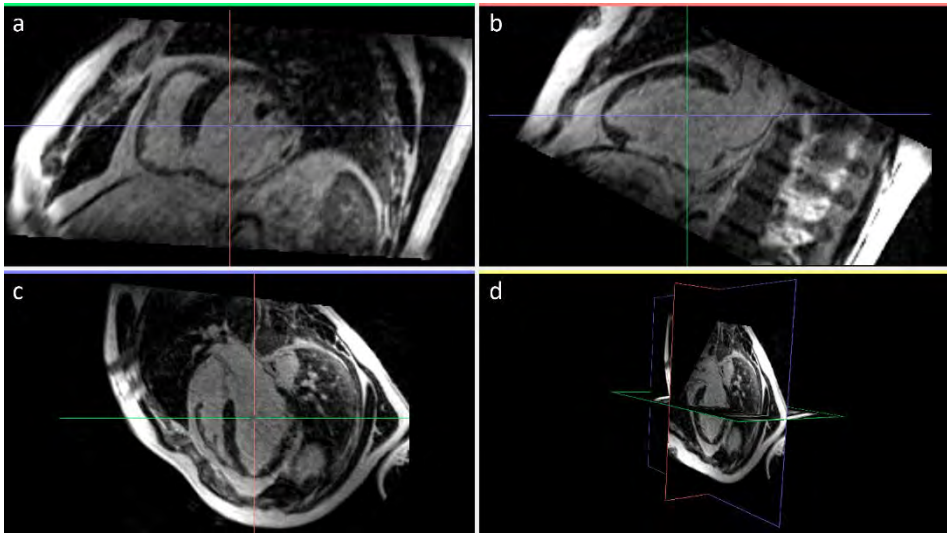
Cardiac DE-MRI stack rotated from standard to cardiac planes with Gimias. Different views of reformatted DE-MRI stack showing slices in the three orthogonal cardiac planes: (a) short axis, (b) long axis or two-chamber view, (c) four-chamber view and (d) 3D view of orthogonal cardiac planes.
